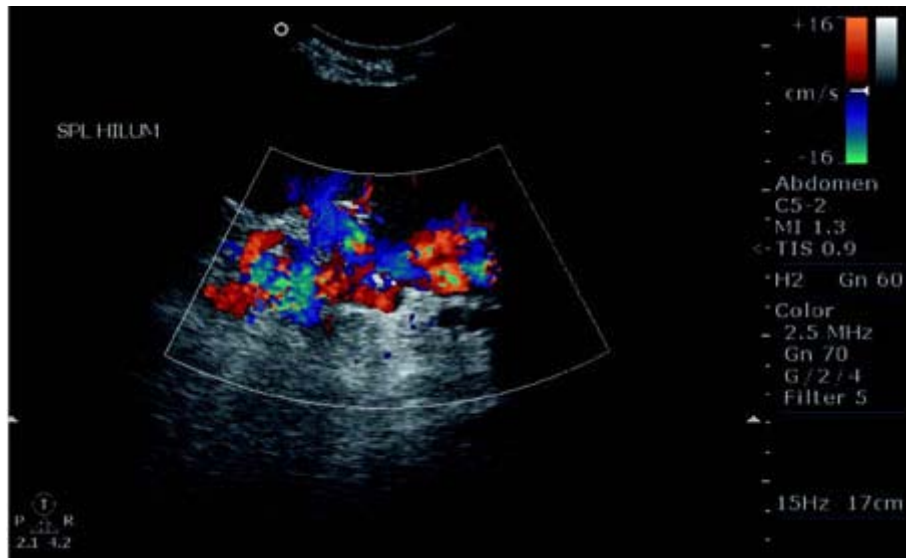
Colour doppler shows splenorenal collaterals.
